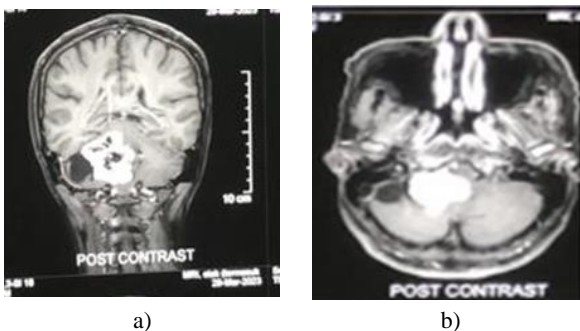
Head MRI Contrast
